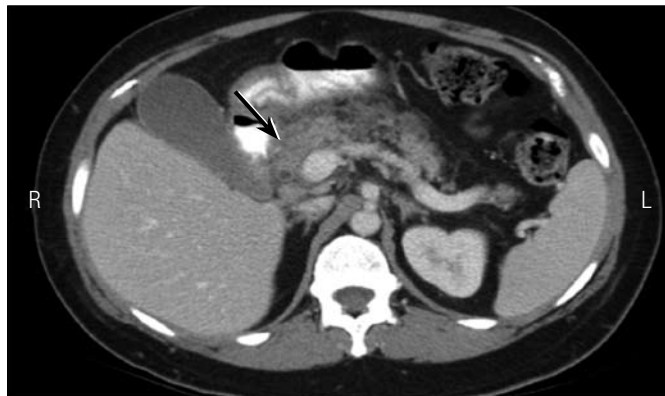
CT scan showing acute pancreatitis with surrounding inflammation.
